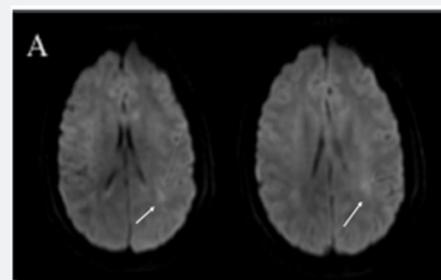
Initial MRI showing DWI restriction within the subcortical white matter in the periventricular regions.
